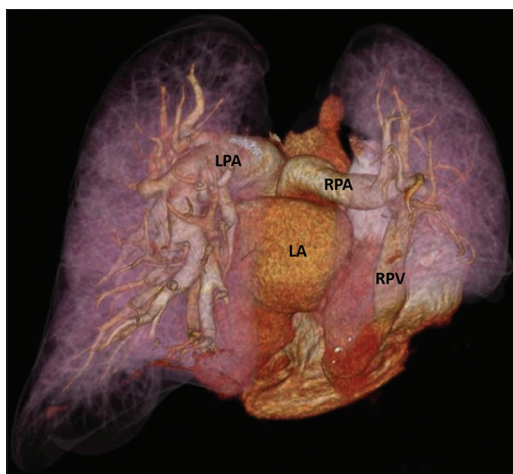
3D volume-rendered computed tomography angiography image (posterior view) shows the absence of communication between left atrium and right-sided pulmonary veins. The right-sided pulmonary veins are emptying into the inferior vena cava. Also note the hypoplastic right lung. LA: Left atrium, LPA: Left pulmonary artery, RPA: Right pulmonary artery, RPV: Right pulmonary veins
